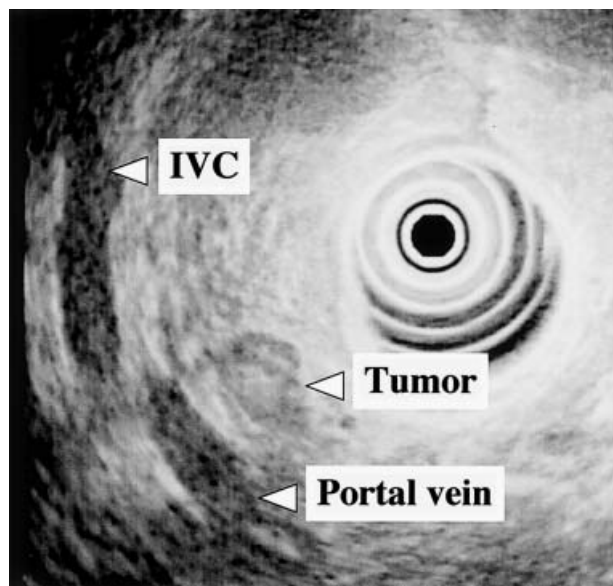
Endoscopic ultrasonography detected a hypoechoic mass 3×2 cm in diameter in the pancreatic head.
